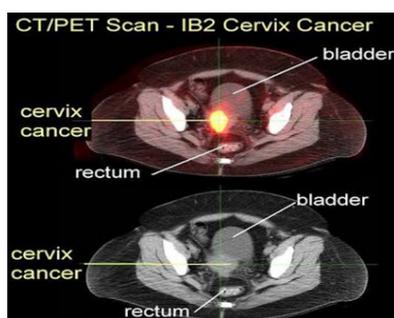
PET-CT scan of cervix cancer. Adapted from: About cancer- PET scans are even better than CT scans [41].
